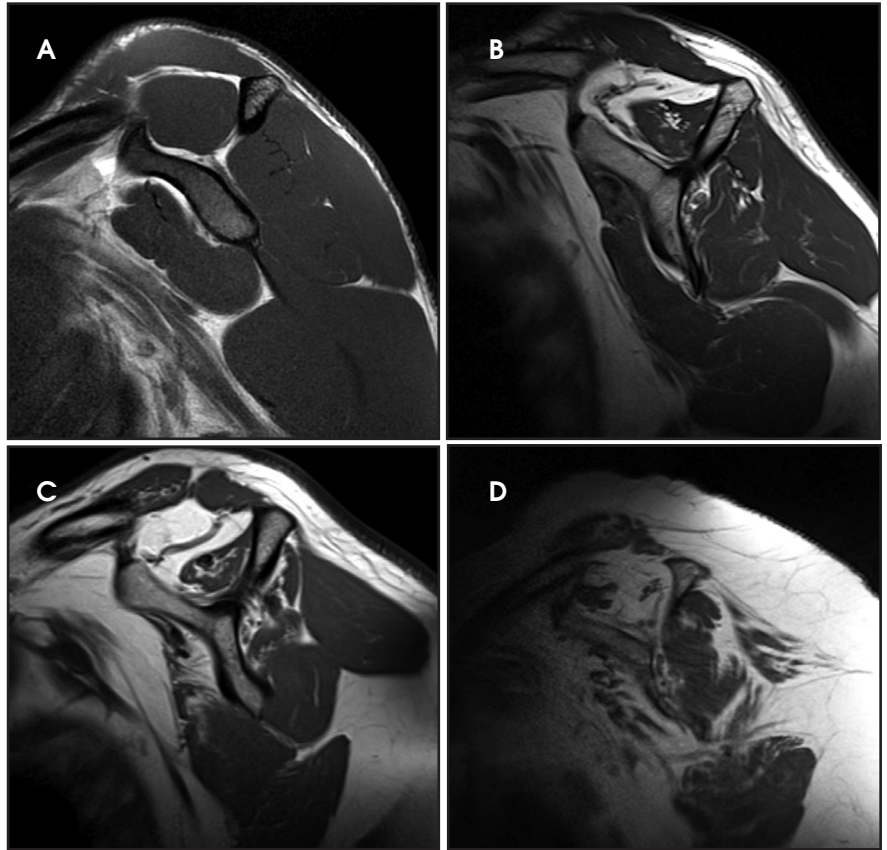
(A) Sagittal oblique T1-weighted (T1W) image demonstrates normal rotator cuff musculature. (B) Sagittal oblique T1W image shows mild supraspinatus and infraspinatus volume atrophy (each is even with its tangent line) and only minimal fatty infiltration. (C) Sagittal oblique T1W image demonstrates moderate volume atrophy and fatty infiltration of the supraspinatus and infraspinatus muscles. There is also severe atrophy and advanced fatty infiltration of the superior aspect of the subscapularis muscle. (D) Sagittal oblique T1W image shows severe atrophy and advanced fatty infiltration of the supraspinatus and subscapularis muscles.
